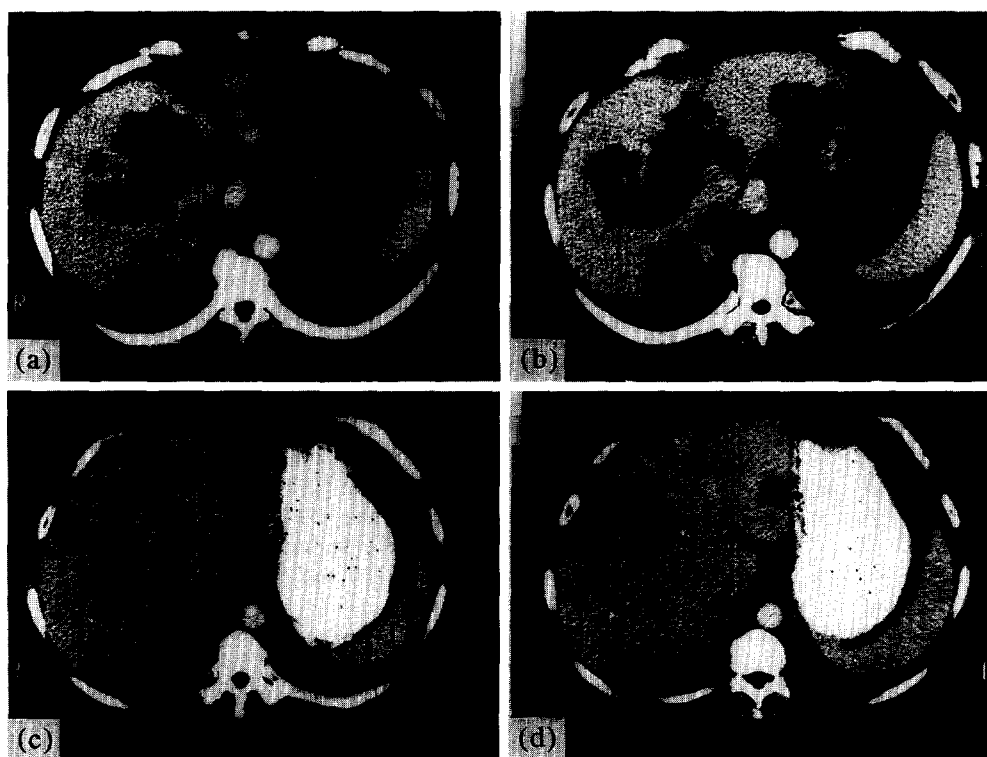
CT scans demonstrating major objective response to CPT-11 and leucovorin. The patient had colon cancer metastatic to the liver. (a) and (b) are from the CT scan taken after tumour progression following 1 year of 5-FU and high-dose leucovorin. (c) and (d) are from the patient's CT scan taken approximately 12 weeks later, after receiving treatment with CPT-11, 5-FU and leucovorin weekly for 4 weeks, followed by a 2-week break.
